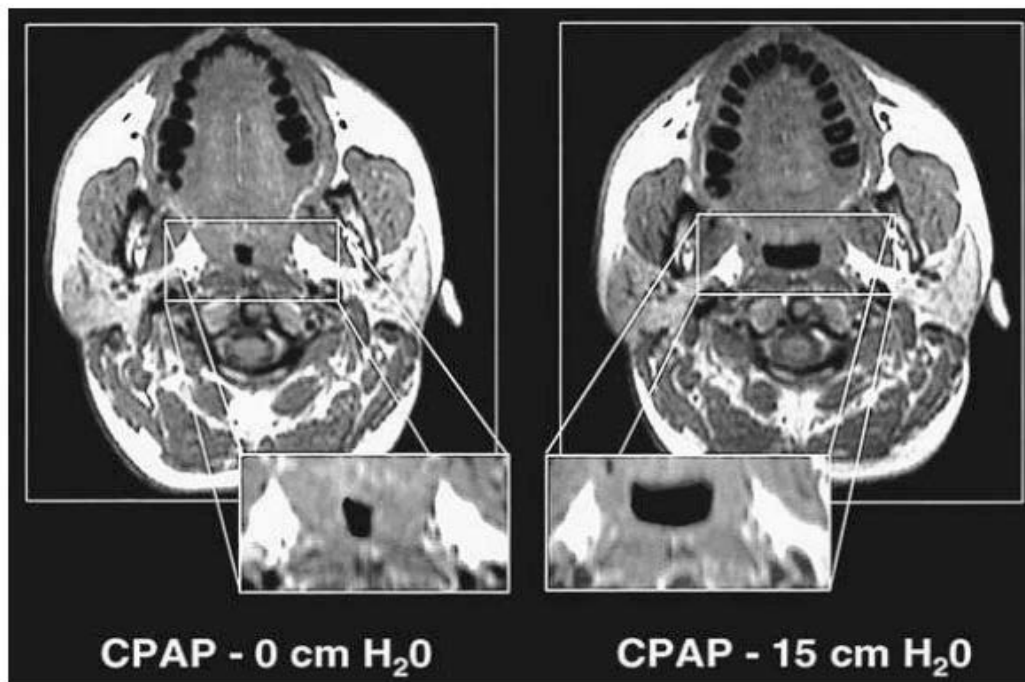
Axial MR image at the retropalatal region in a normal subject with 0 cmH₂O and CPAP of 15 cmH₂O. Airway enlargement is demonstrated predominantly in the lateral dimension with the application of 15 cmH₂O of CPAP. The anterior-posterior airway dimension is not significantly changed with CPAP at 15 cmH₂O (*Terri et al., 2010*).
